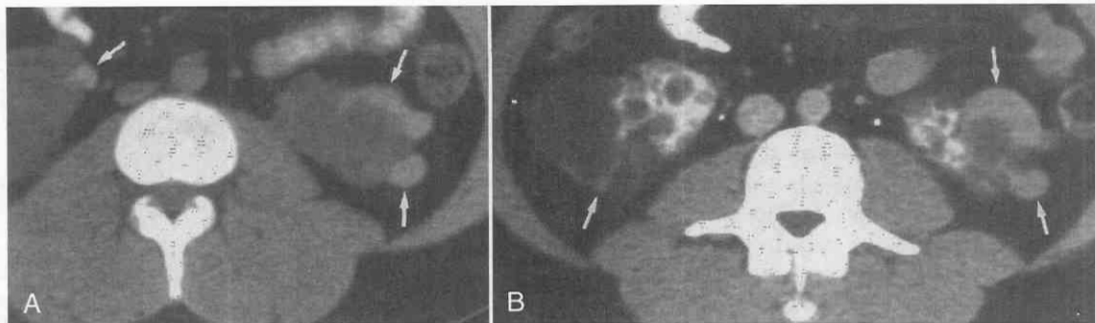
Hemorrhagic renal cysts in autosomal dominant polycystic kidney disease. *A*, Unenhanced CT scan shows bilateral subcapsular high-density cysts (arrows). *B*, After IV contrast enhancement, the high-density cysts (arrows) are hypodense relative to enhanced residual renal parenchyma. Many fluid-density cysts are present. The high-density cysts had an average attenuation value of 70 HU on both precontrast and postcontrast scans.
